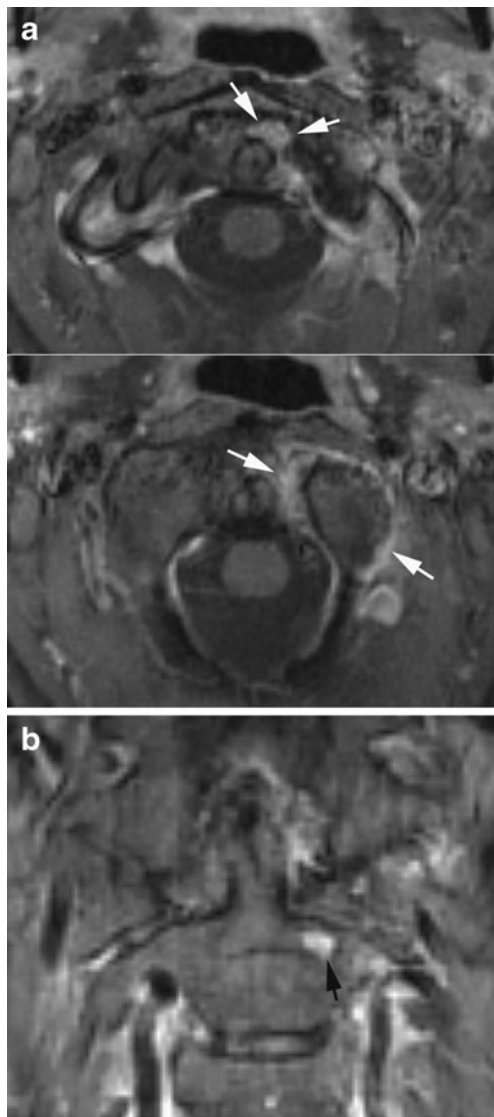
Non-radiographic MR findings.* MRI in a 41-year-old woman with peripheral erosive RA and neck pain, but normal cervical radiography. (a) Post-contrast axial and (b) coronal T1FS images show signs of active arthritis with synovial contrast enhancement at the left atlanto-axial joint in addition to enhancing pannus tissue at the left side of the dens (white arrows). There is also a subchondral enhancing area in the axis (black arrow) compatible with a pre-erosive lesion
